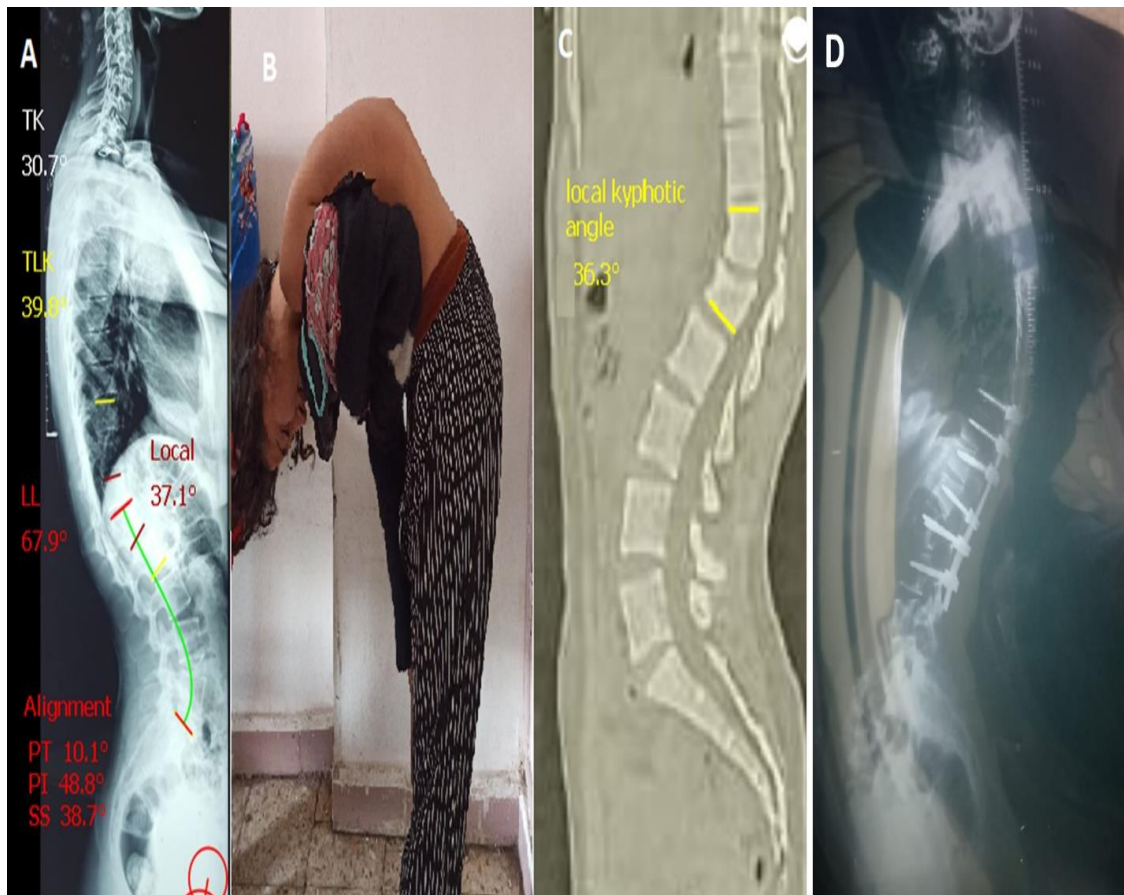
Female patient 20 years old with L1 fracture managed conservatively. A) Sagittal longstanding X-ray preoperative. B) clinical photo preoperative. C) Sagittal cut CT view preoperative. D) One year follow up after 3 Ponte osteotomies with fixation T10-L3.
